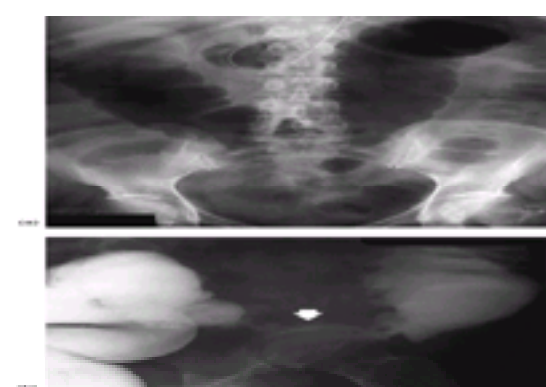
(a) Plain film of a patient with large-bowel obstruction caused by a diverticular stricture. (b) The point of narrowing (arrow) and the dilated proximal colon are well demonstrated in this spot view from a contrast study.
